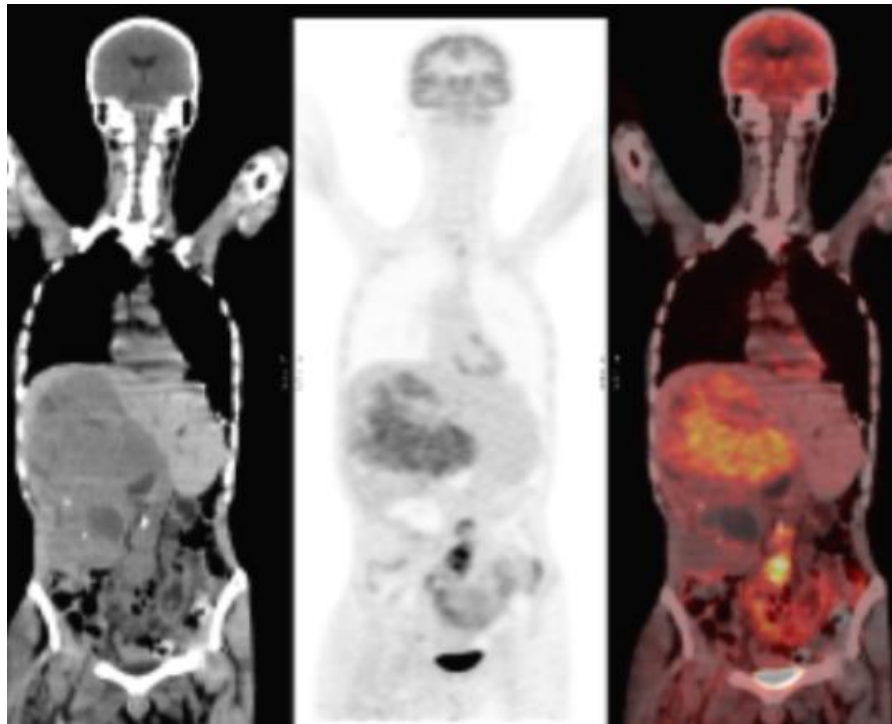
33 years old male, with duodenal GIST with metastases to liver and lymph nodes on Imatinib mesylate starting from 2009. PET CT Coronal fused images revealed partial remission with residual FDG avid metastatic hepatic focal lesions with multiple FDG avid para aortic lymph nodes.
